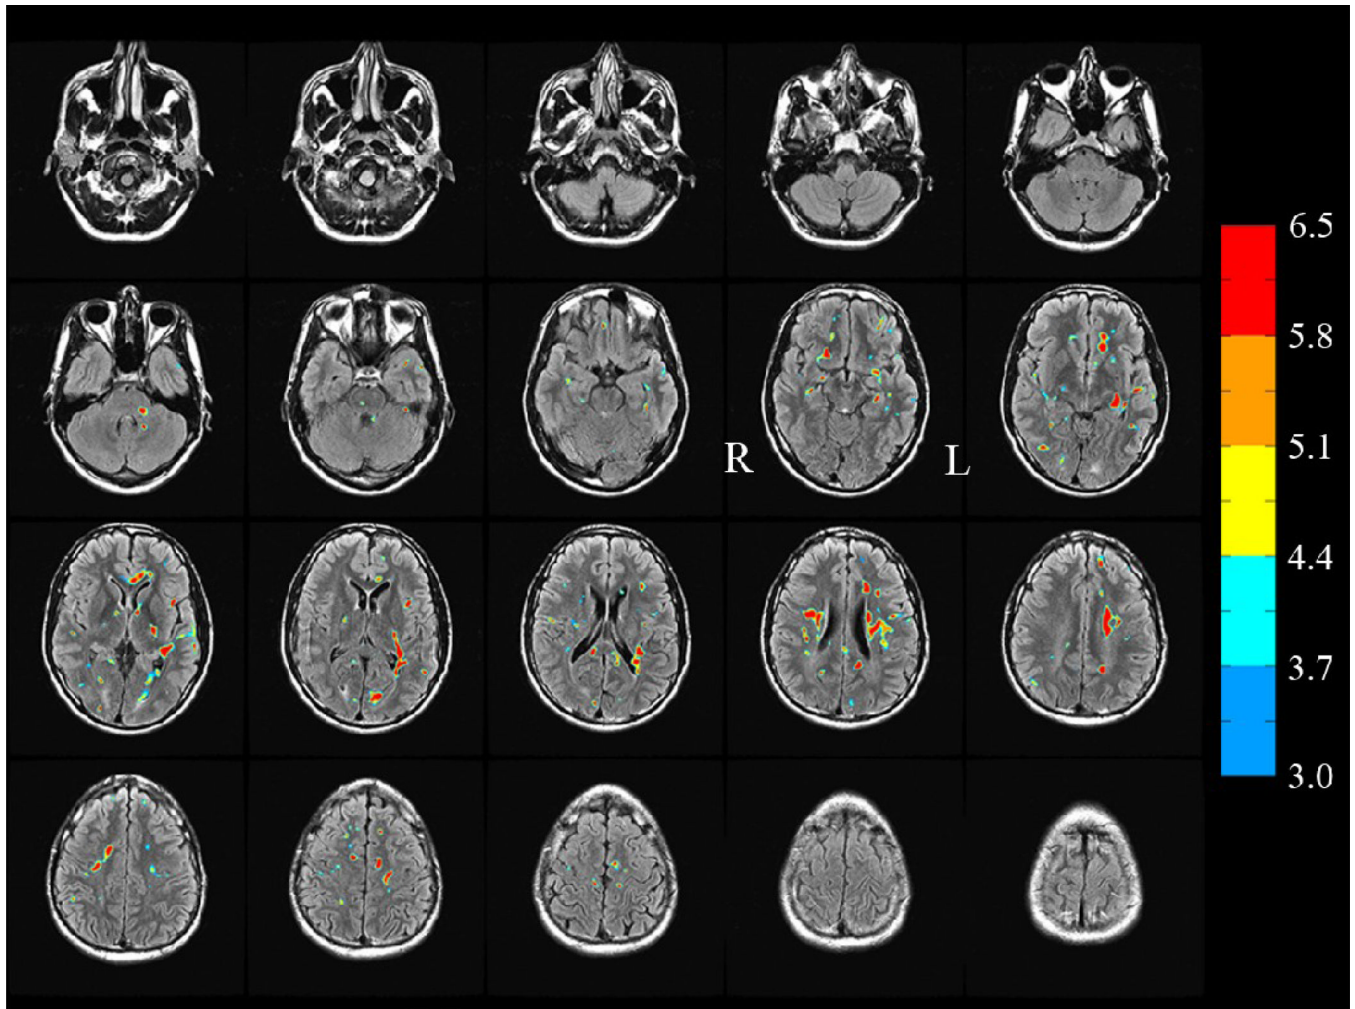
Similar to Fig. 5, the FA reduced regions for TBI subject 2 superimposed on the FLAIR images of the subject. (In this montage, the left hemisphere L appears at the right in each image).
